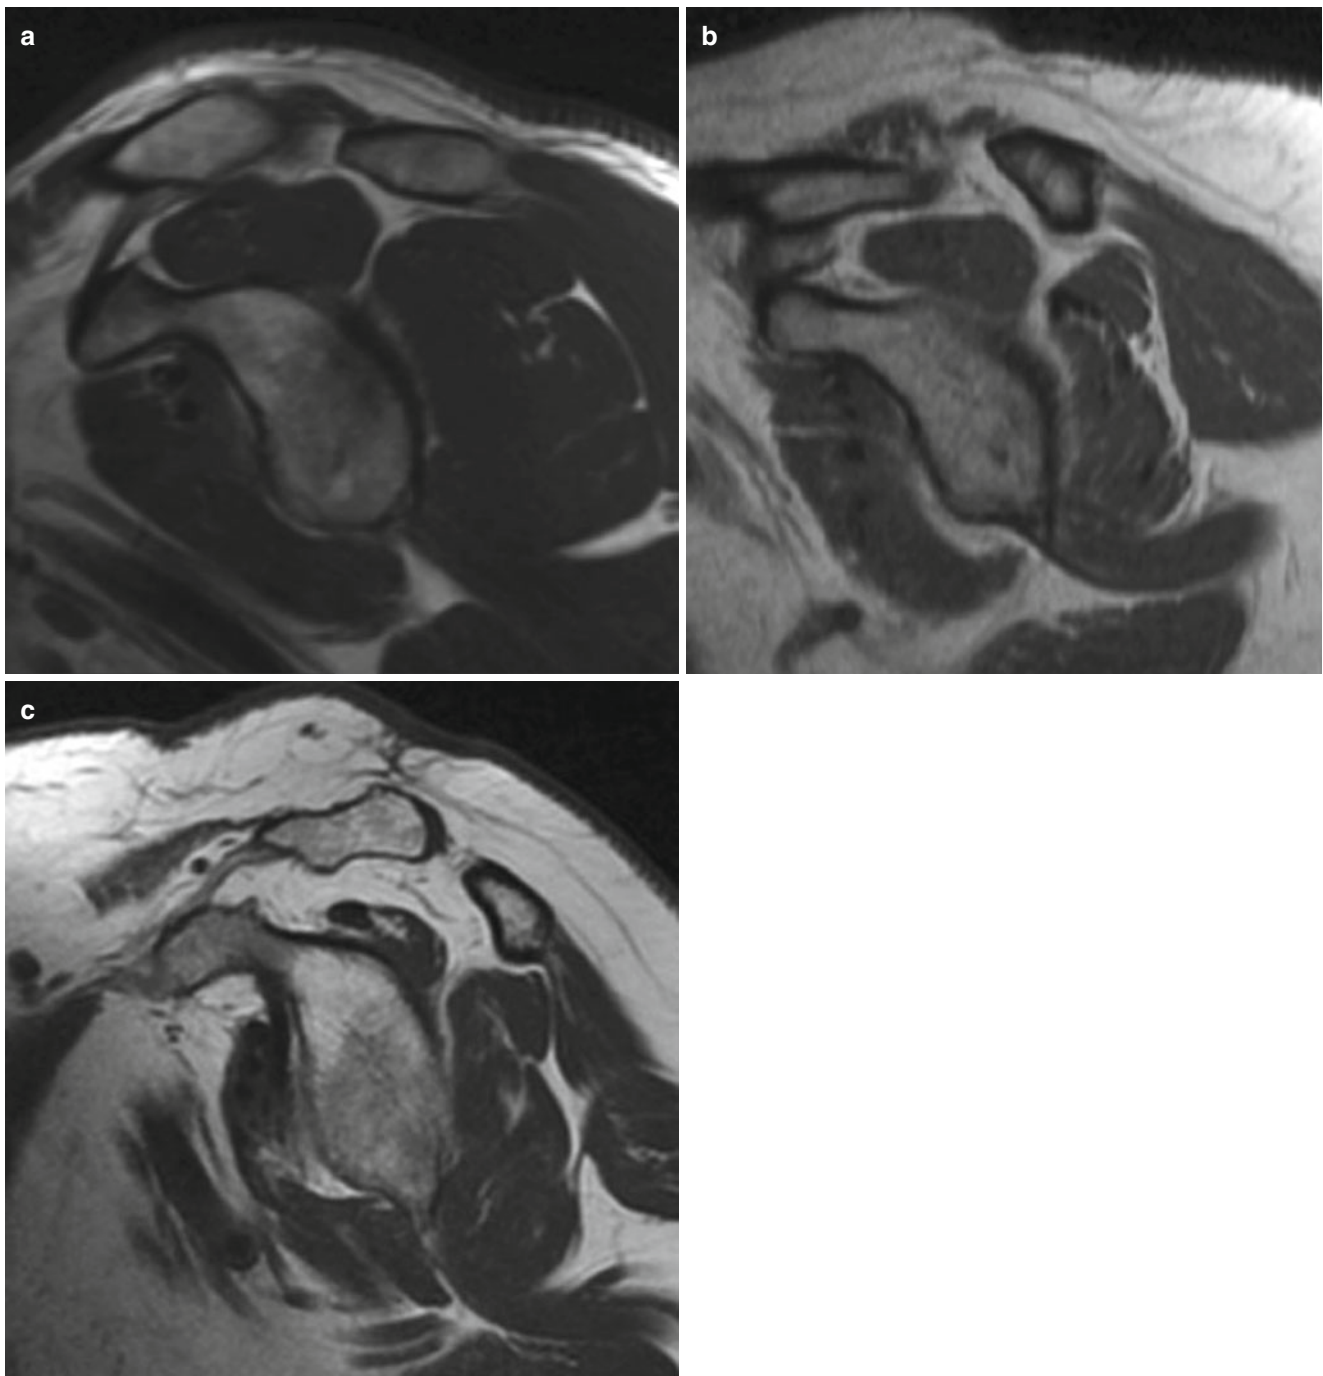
T1-weighted image with fatty involution of the supraspinatus muscle in oblique sagittal, according to Fuchs et al. [57]. (a) Grade I: some fatty streaks. (b) Grade II: less than 50 % fatty muscle atrophy. Grade III: 50 % fatty muscle atrophy. (c) Grade IV: greater than 50 % fatty muscle atrophy
